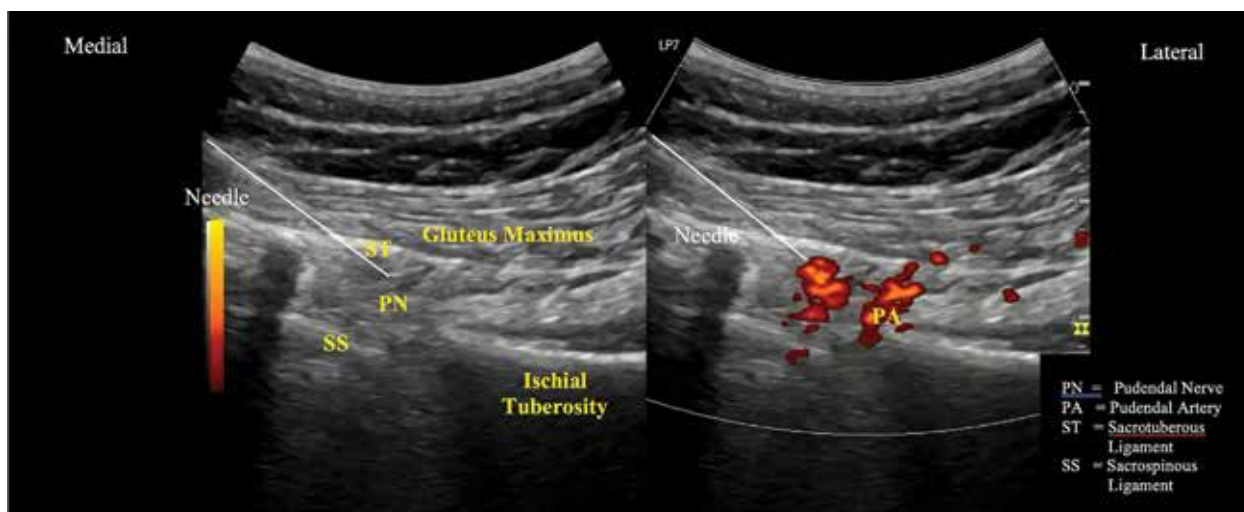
Ultrasound-guided PN dextrose hydrodissection between ST and SS ligaments. PN, pudendal nerve; PA, pudendal artery; ST, sacrotuberous; SS, sacrospinous.
